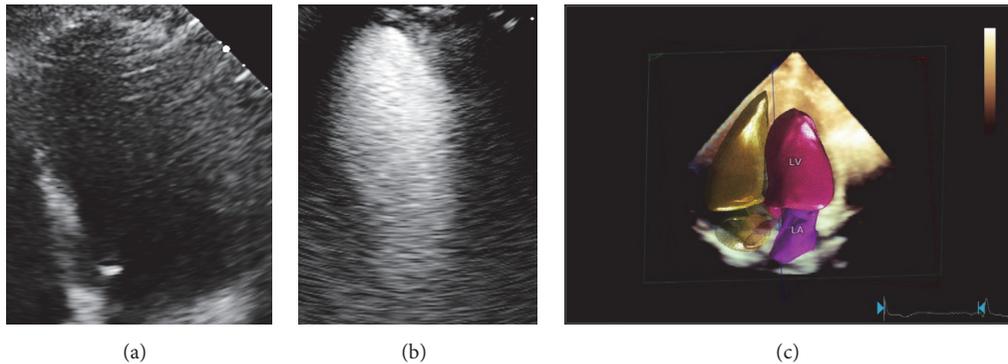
Dobutamine stress echocardiography in patient affected by diabetes mellitus (DM) with chronic pulmonary obstructive disease (COPD) and poor acoustic window. (a) Apical four-chamber view of left ventricle. (b) The use of ultrasound contrast agent definitively allows an acceptable imaging quality of the endocardial border. (c) 3D heart model is imaged. It represents a chamber quantification using a model-based segmentation algorithm for achieving a more accurate functional assessment.
